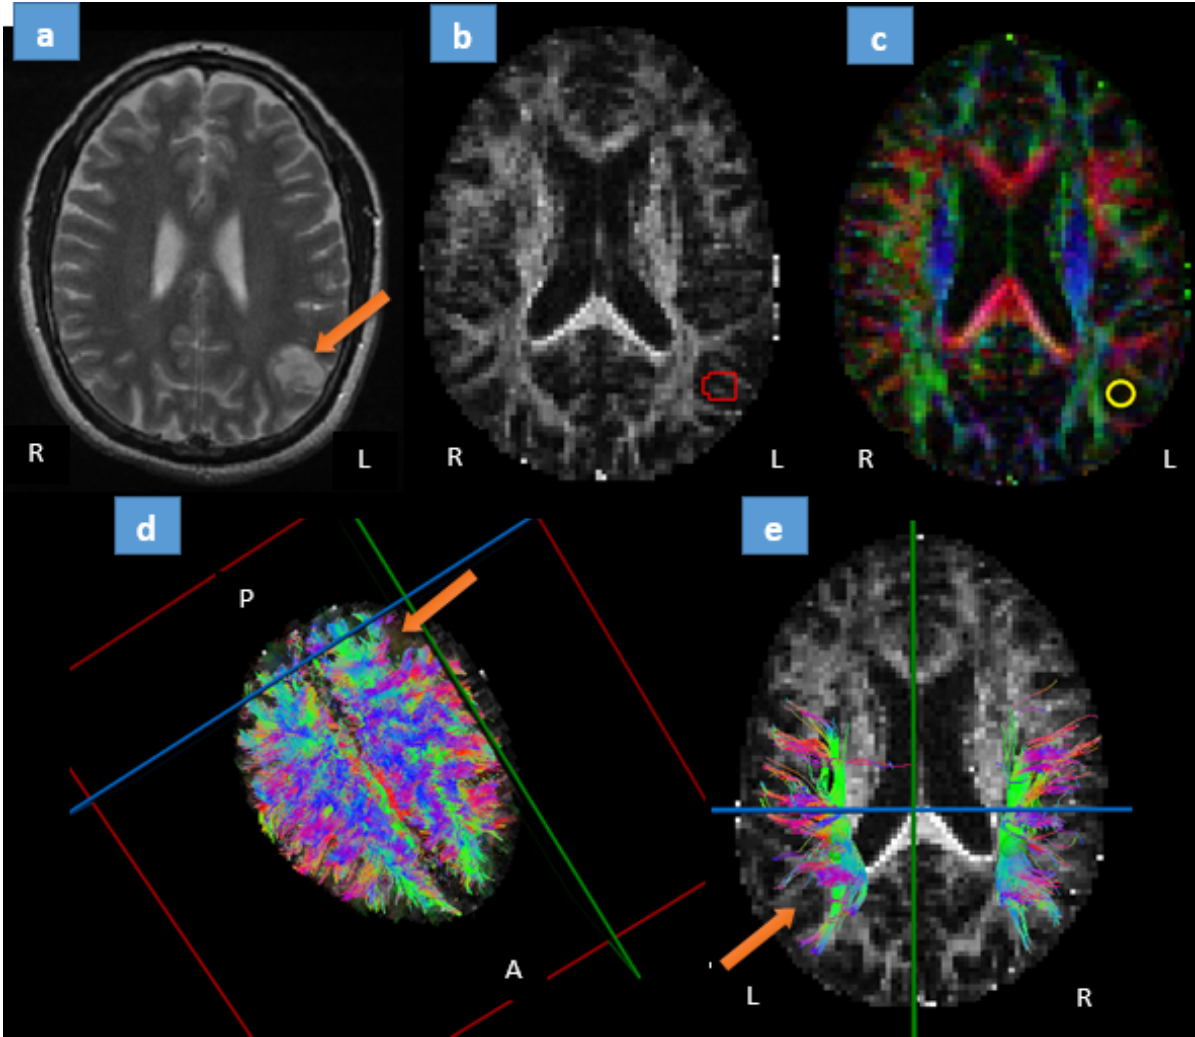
Patient with Astrocytoma grade II - T2-weighted image (a) shows the tumor in Wernicke's area. Fractional anisotropy (FA) map (b) shows a slight decrease in FA value (red region). The same region is shown in color-coded map (c) (yellow circle). 3D whole brain tractography (d) shows the tumoral region void of white matter tracts (arrow). 3D fiber tractography initiated in ROI (d) on the left hemisphere, shows the displacement of fibers around the tumor. The counterpart tract on the right hemisphere is shown for comparison. A: Anterior. P: Posterior. R: Right. L: Left.
